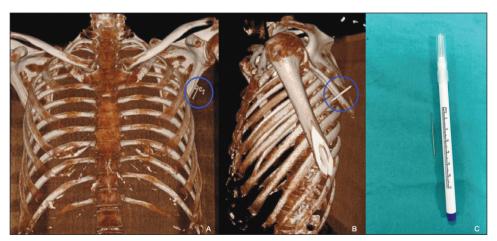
A, B) The appearance of the foreign body and its location on the chest wall in thorax CT images using the 3D method (blue circle); C) Image of the surgically removed foreign body (Sewing needle).
